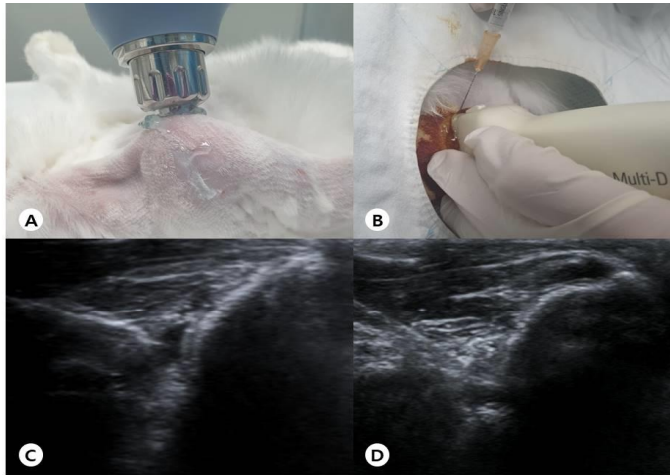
ESWT was performed (A) after (G3-PDRN+ESWT) or before (G4-ESWT+PDRN) 0.2 mL of PDRN injection (B) into FTRCTT under US guidance (C-D). Abbreviations are ESWT, Extracorporeal shockwave therapy; PDRN, Polydeoxyribonucleotide; US, Ultrasound
